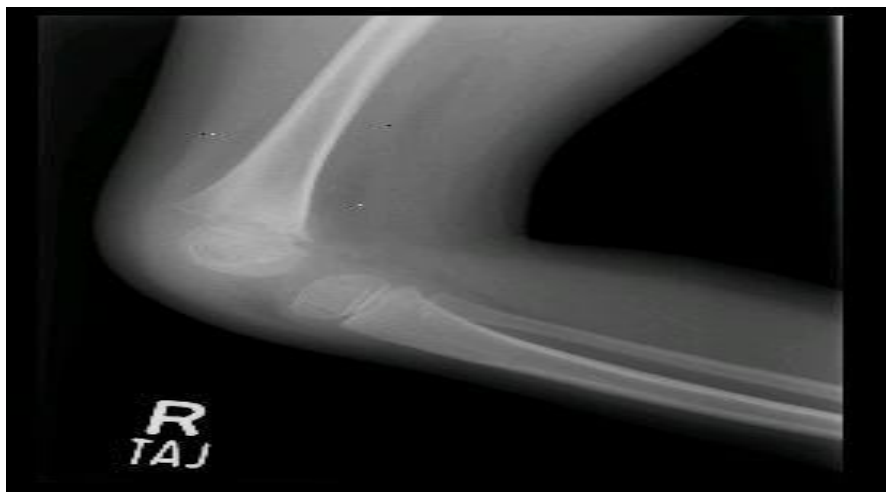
Plain radiograph of elbow joint showing osteopenia and erosion.
